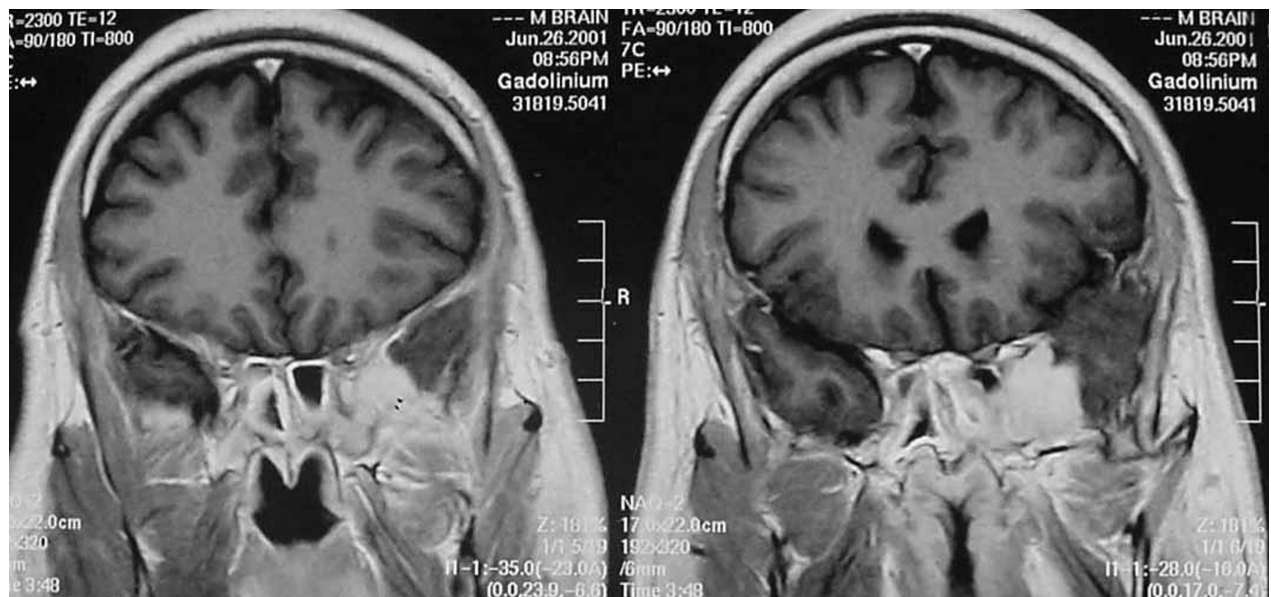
(a) T-2 weighted MR imaging (axial sections) showing a mass lesion in the left middle cranial fossa producing extremely hypo-intense signals. (b and c) Post-gadolinium enhanced T-1 weighted image (axial and coronal sections) of the same patient (as in a) showing bright contrast homogenous enhancement of the mass lesion. There is also involvement of the adjacent sphenoid sinus with mucosal thickening
